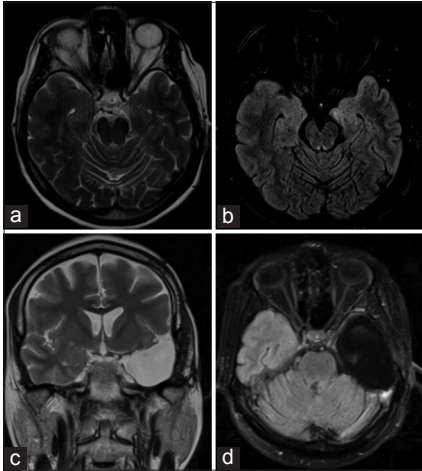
A 23-year-old male who presented with complex-partial seizure had right-sided mesial temporal lesion on axial T2-weighted (a) and fluid-attenuated inversion recovery (FLAIR) magnetic resonance images (b). The temporal cortex appeared normal. The radiological examination at the last follow-up showed no tumor recurrence on coronal T2-weighted (c) and axial FLAIR images (d) and the patient was seizure-free.
